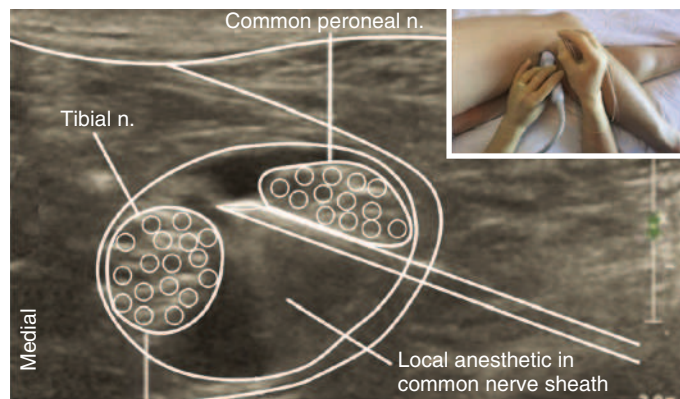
Ultrasound-guided popliteal nerve block. The most convenient positioning in the acutely injured patient is often lateral decubitus with the injured leg superior, as shown here. The bifurcation of the sciatic nerve is targeted using an in-plane, lateral-to-medial approach. Local anesthetic should be seen to flow around both the tibial and the peroneal component of the sciatic nerve.
